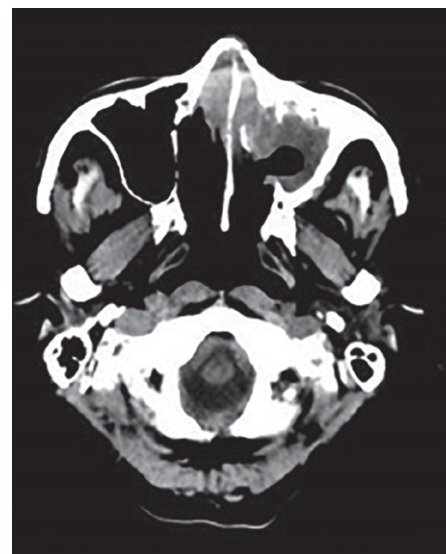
CT scan of the sinus showed a poorly delineated mildly expansile mass, the left nasal cavity and severe mucosal disease of the left maxillary sinus, left frontal sinus, and left mucosal air cells.
